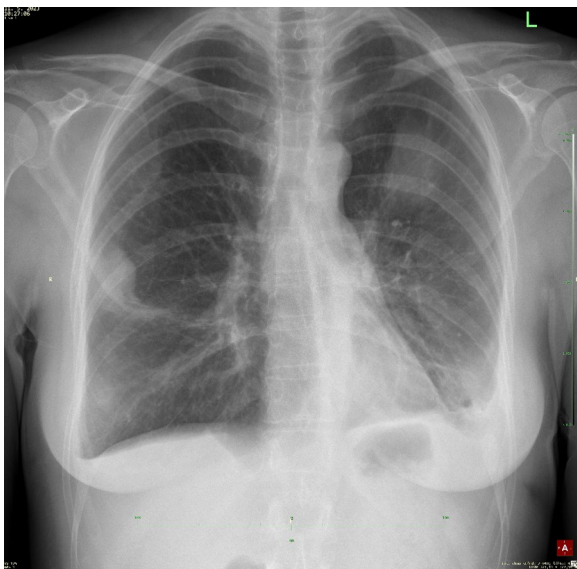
Follow-up chest X-ray 7 weeks after discharge from hospital showing further improvement in the transparency of both lung wings
